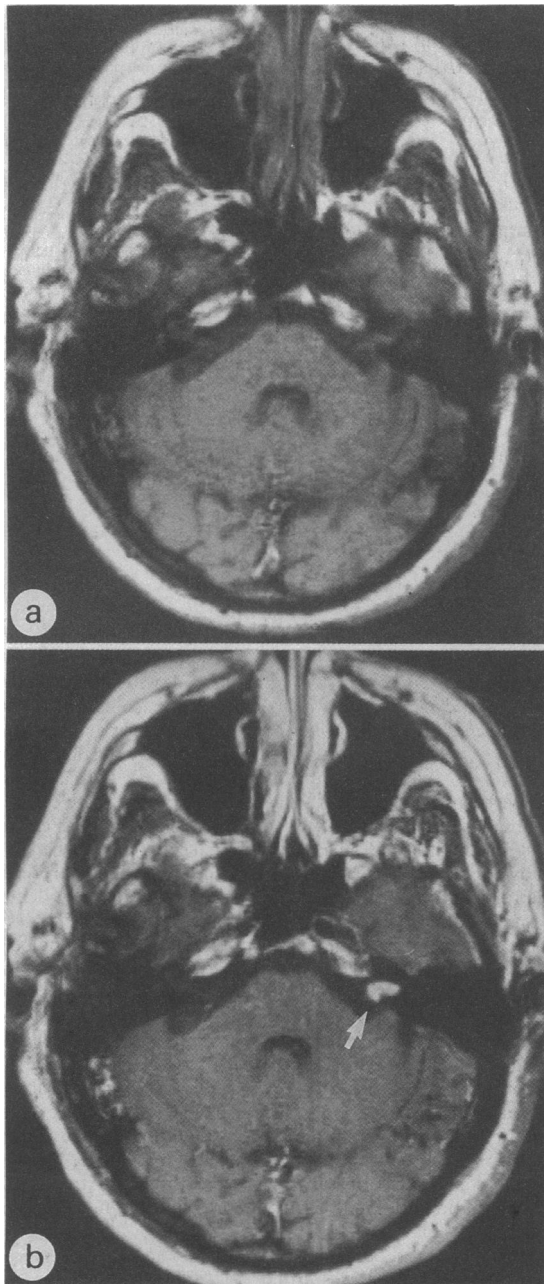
Magnetic resonance image of acoustic neuroma. The tiny acoustic neuroma in the left internal auditory canal (arrow) is identifiable only in (b), taken after an intravenous injection of gadolinium DTPA. Both images are T1 weighted axial sections through exactly the same level
